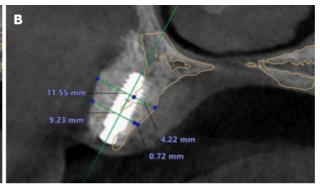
Cone beam computed tomography superimposed images before bone grafting and after implantation. A: At site of implant 12. The yellow line represented the alveolar ridge before bone grafting. The bone width was increased from 1.83 to 8.83 mm at a point 5 mm below the crest, and from 1.70 to 9.47 mm at a point 10 mm below the crest; B: At site of implant 14. The yellow line represented the alveolar ridge before bone grafting. The bone width was increased from 0.72 to 9.23 mm at a point 5 mm below the crest, and from 4.22 to 11.55 mm at a point 10 mm below the crest.
